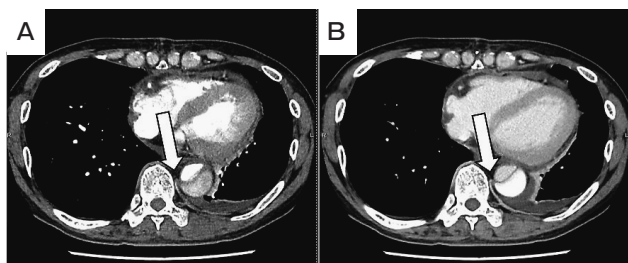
Postoperative enhanced CT in the descending aorta. Postoperative enhanced CT revealed delayed enhancement of the non-thrombosed false lumen in the descending aorta. A, arterial phase; B, late phase; white arrowhead, left intercostal artery at the Th9 level from the false lumen.
